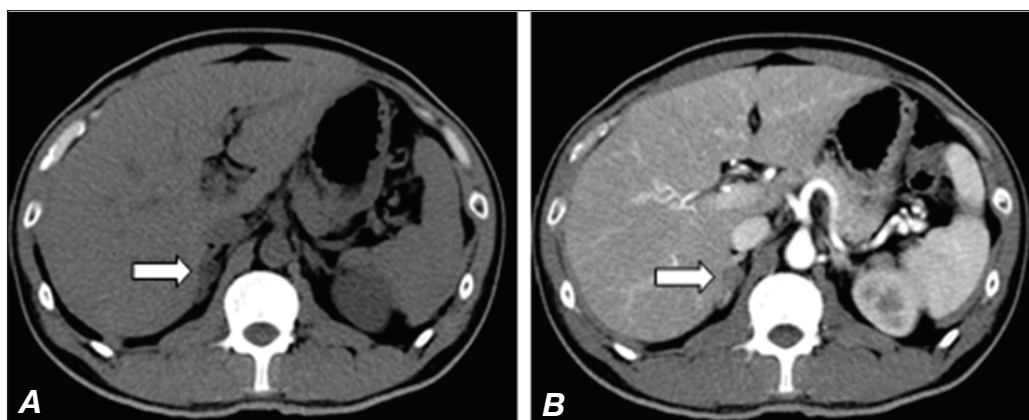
Computed tomography: Nodular mass on the right adrenal gland (arrow in A) with homogenous enhancement (arrow in B).
